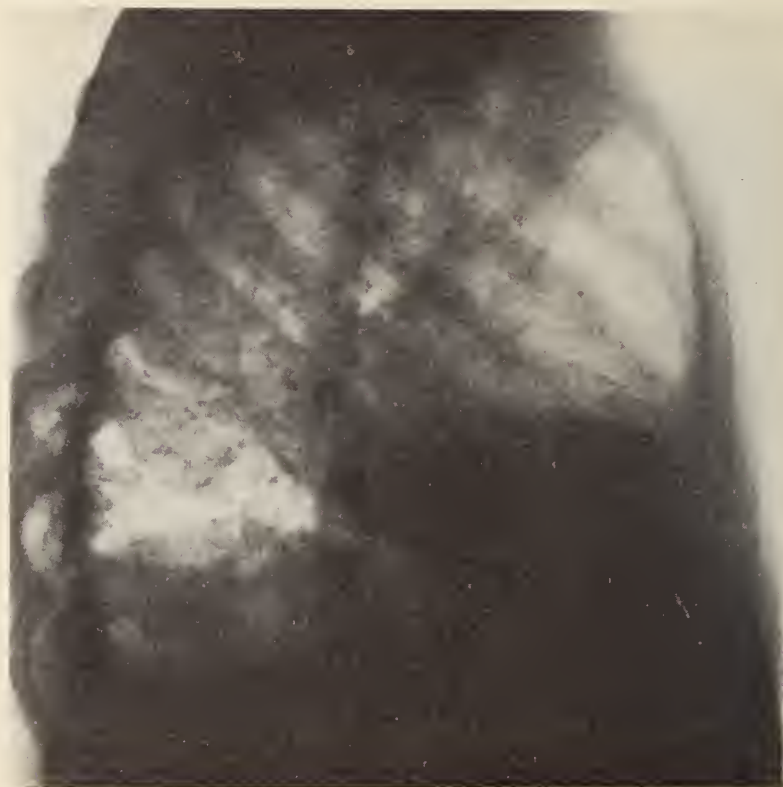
Lateral view of roentgenogram taken December 17, 1936 showing consolidation to be in the right middle lobe.
